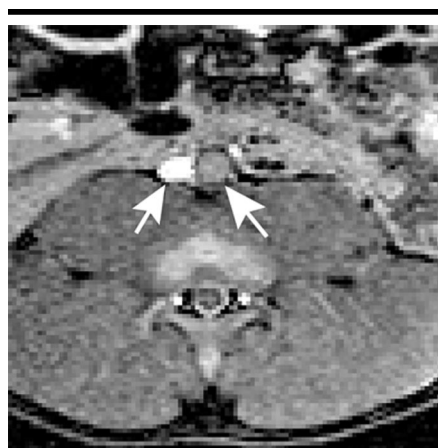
Transverse balanced FFE (2.7/1.4; flip angle, 50°; section thickness, 8 mm; field of view, 260 mm; matrix, 256 × 256) MR image shows decreased SI in the lumen of a nitinol stent placed in the aorta (right arrow), compared with SI in the adjacent vena cava (left arrow).
